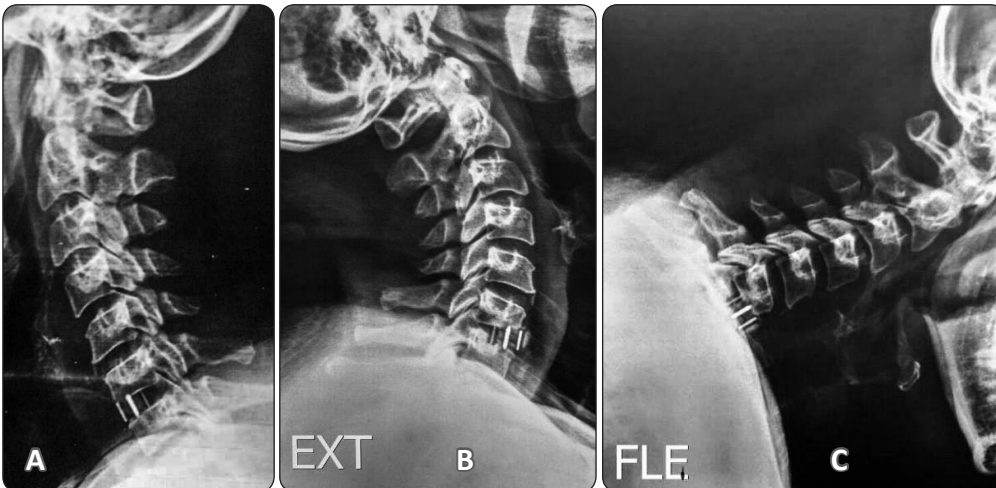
A: immediate postoperative X-ray cervical spine ACDF C6-7 b and c: 3 months postoperative X-ray cervical spine showing non-fusion and graft extrusion.
